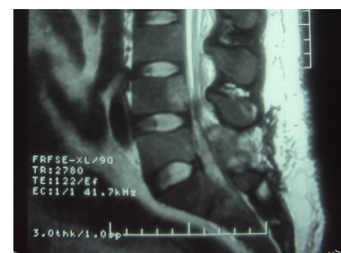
Sagittal T1-weighted Magnetic Resonance Image (MRI) of the lumbosacral spine showing tumor at the L5 and sacral vertebral.
